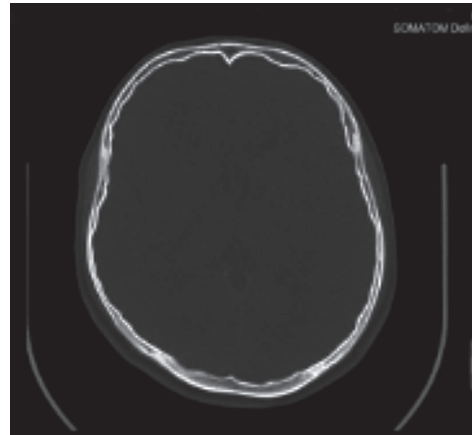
Computed tomography scan of the skull.
